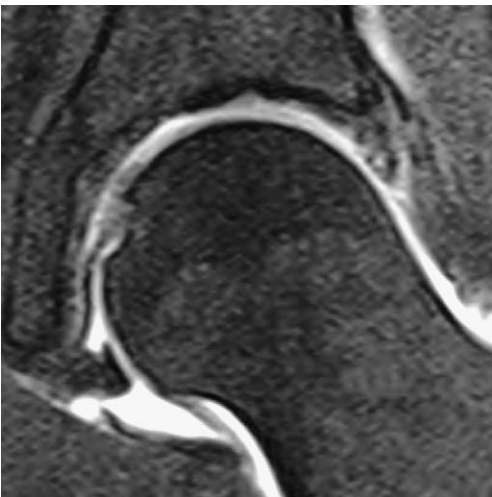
On this coronal fat-saturated T1-weighted image with intra-articular gadolinium, the superior labrum has diffuse heterogeneous intermediate signal within. A tear is confirmed along the articular surface with the intra-substance collection of contrast material.
